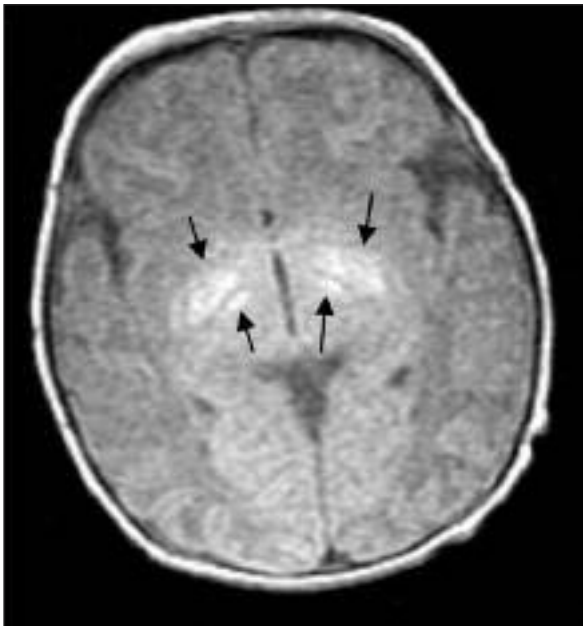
T1-weighted MRI shows symmetric, hyperintense GP involvement and subthalamic involvement.
